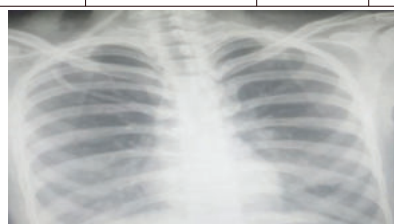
Chest X-ray PA view of case number 3 on admission showing bilateral lower zone haziness
